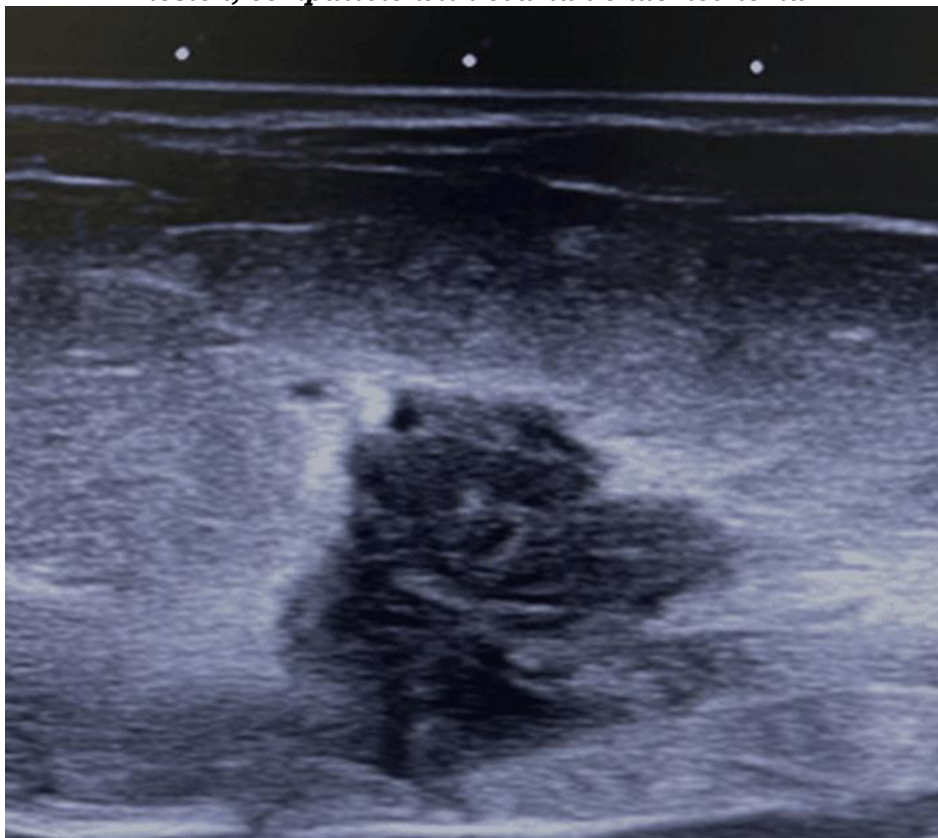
Transabdominal ultrasound image showing a heterogeneous hypoechoic subcutaneous lesion at a cesarean-scar site, consistent with subcutaneous cesarean-scar endometrioma
